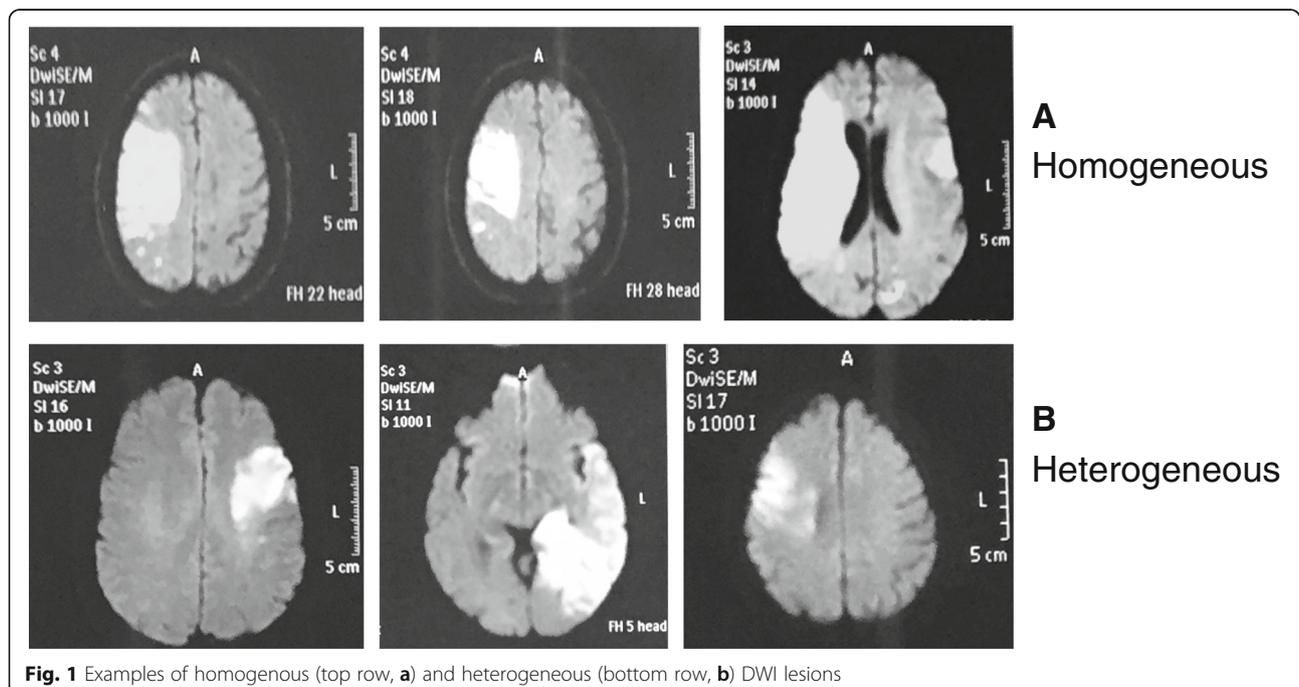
Examples of homogenous (top row, a) and heterogeneous (bottom row, b) DWI lesions
